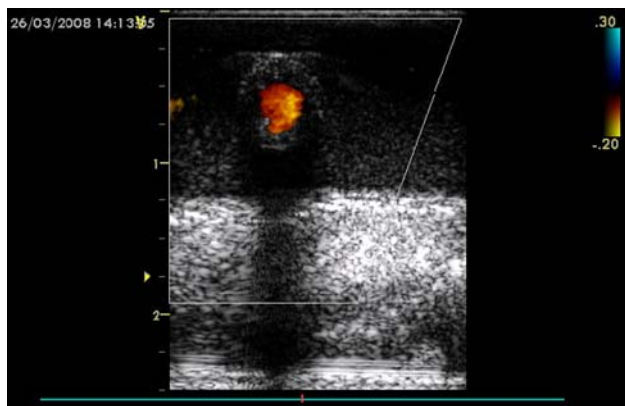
Axial color Doppler image of the vascular system
